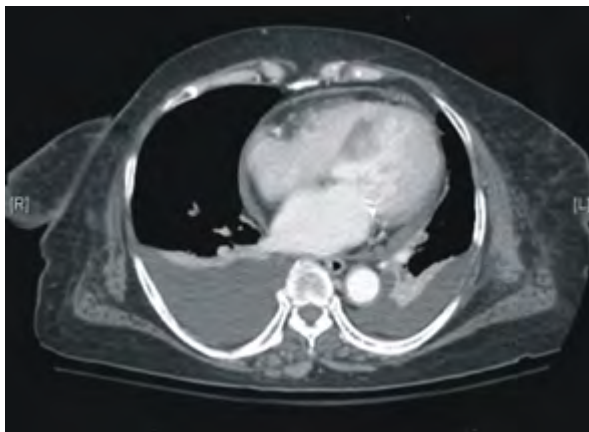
A) Transthoracic echocardiogram shows cardiac tamponade one hour after ethanol injection. B) Computed tomogram shows a massive bilateral pleural effusion one week after alcohol septal ablation.
